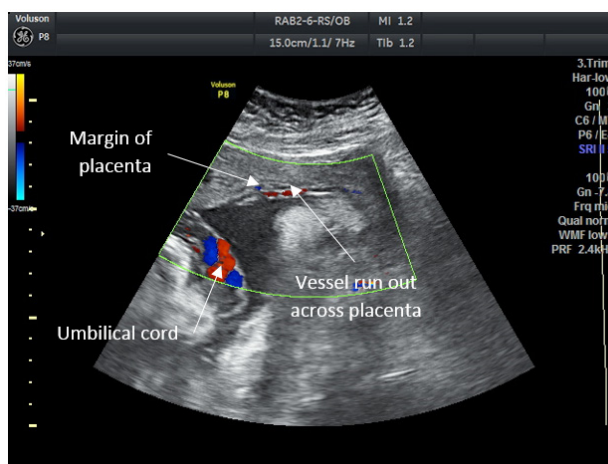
Color Doppler Confirmation of The Blood Vessel Inserted into The Lower Margin of Placenta
